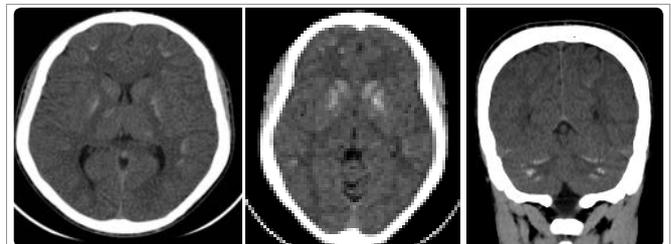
CT image without contrast injection in axial section (A and B) and in coronal reconstruction (C), showing bilateral and symmetrical calcifications of basal ganglia located at A on the pallidum and the white-gray junction, in B on the lenticular nuclei, the heads of the caudate nuclei, and in C on the cerebellar hemispheres (serrated nuclei).
